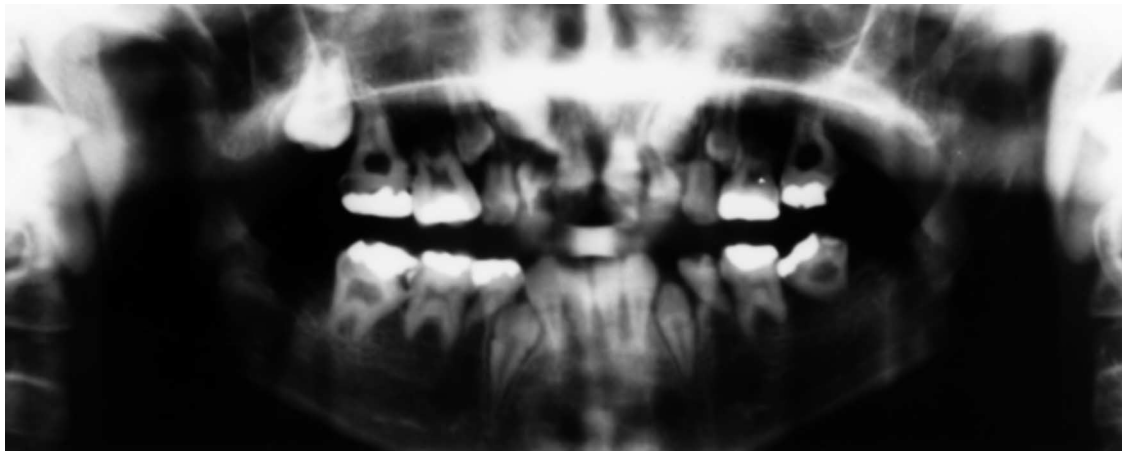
An 11-year-old girl treated with bone marrow transplantation at 2.2 years of age receiving 10-Gy total body irradiation. The panoramic radiograph shows v-shaped short roots, enamel hypoplasia, microdontia, and multiple missing teeth.
